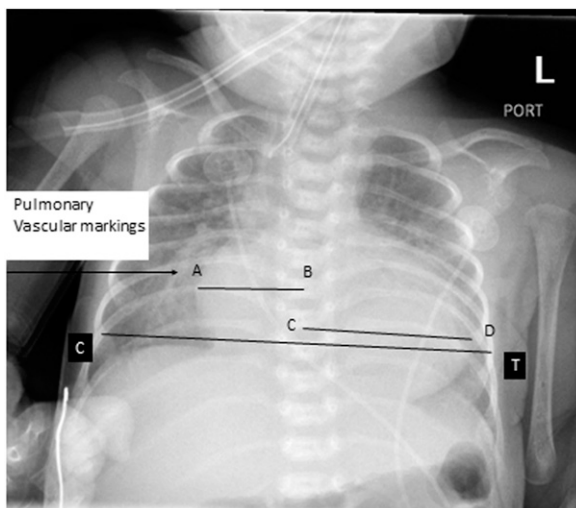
Chest radiograph with landmarks used to diagnose cardiomegaly.
